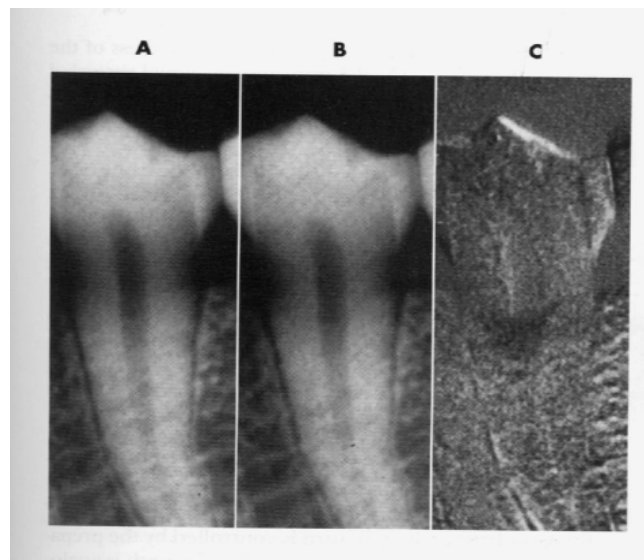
Digital subtraction radiographs. Subtraction radiography requires two images (A&B), which are exposed with the same geometry. In this instance the loss of alveolar bone in "B" is too subtle to be seen, however the subtracted image(C) displays the differences between A&B; the bone loss is seen as a dark structure superimposed over the pulp.(courtesy DR. H. G. Grondahl, Gotenborg, Sweden)
